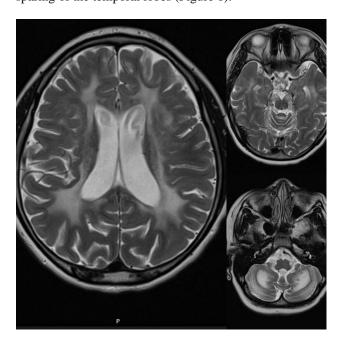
MRI brain with contrast shows severe diffuse profound white matter disease extending from the subcortical white matter to the deep white matter involving the cerebellum and cerebrum with relative sparing of the temporal lobes.
